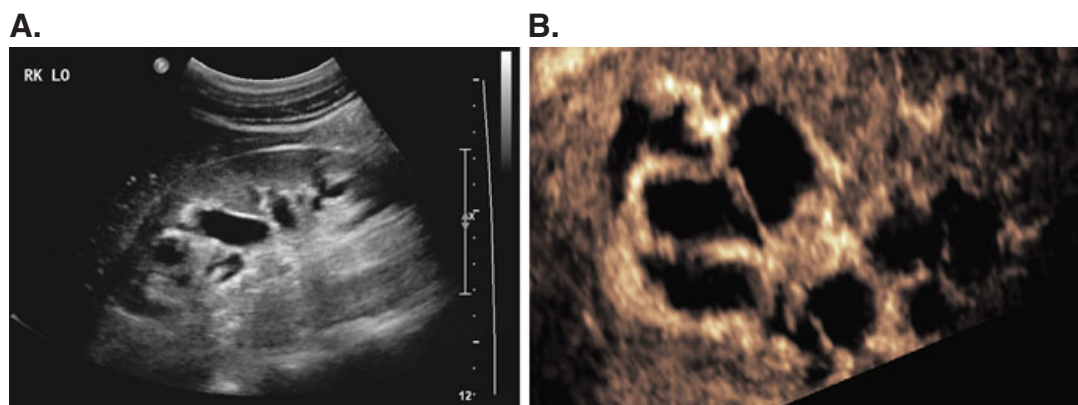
Kidney ultrasonography of 42 year old male with Fabry disease (blood pressure 120/80; eGFR = 73 ml/min/1.73 m²; urine protein/c reatinine ratio = 0.10 g/g on 10 mg/day lisinopril). (A) Conventional gray-scale sagittal image. (B) Coronal reformatted ultrasound false colored image generated from a volume acquisition showing multiple non-communicating parapelvic cysts embedded in the central echo complex of the right kidney (Images courtesy of Franklin Tessler, MD CM, Professor of Radiology, University of Alabama at Birmingham)
